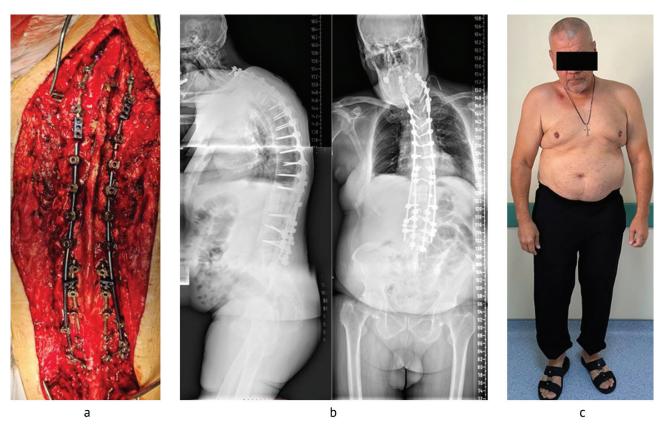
Intraoperative photo of the wound, postoperative survey radiograph and the patient's appearance: (a) definitive appearance of a single metal construct $C_5 - L_4$ without replacement of previous constructs with the connection to new elements using connectors and additional rods; (b) X-ray topogram after surgery showing a single hybrid metal construct $C_5 - Th_2 - Th_3 - L_2 - L_4$ with a four-rod zone at the lumbar level; (c) photo of the patient after the final stage of spinal column reconstruction
